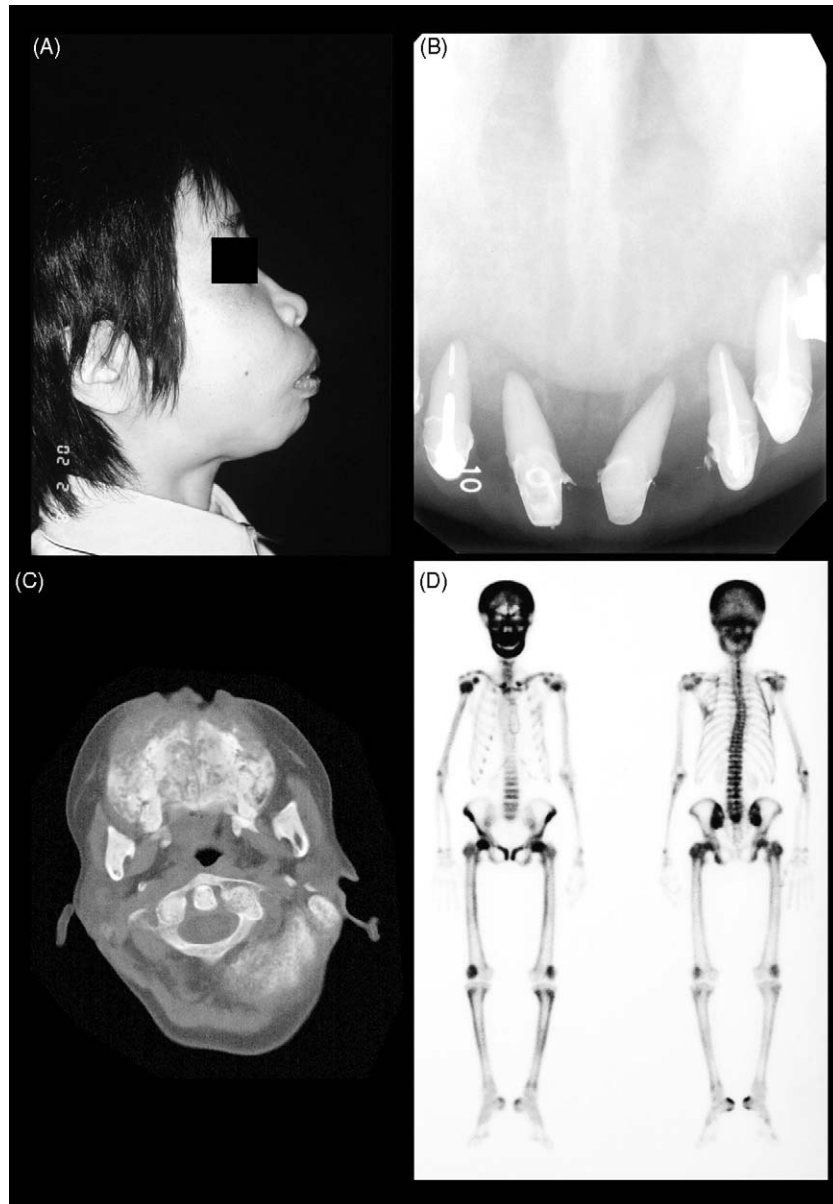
Clinical photograph and radiographic examinations at the first visit. (A) Right lateral view showing enlargement of both jaws. (B) Occlusal radiograph demonstrating loss of the lamina duras. (C) Axial CT section of the maxilla. (D) Bone scintigram of the whole body.
